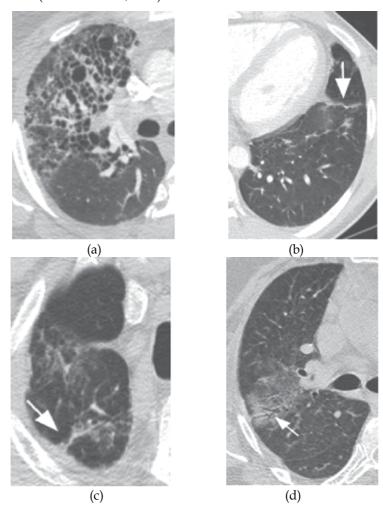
Fibrotic changes in advanced sarcoidosis. (a) A 29-year-old female with sarcodidosis. CT of the chest demonstrates multiple cystic lesions within the left upper lobe, representing areas of honeycombing. (b) A 34-year-old male with sarcoidosis. CT of the chest shows areas of linear densities (arrow) in the left lower lobe compatible with linear scarring. (c) A 49-year-old male with sarcoidosis. CT of the chest demonstrates architectural distortion in the right lung apex (arrow). (d) A 54 year-old female with sarcoidosis. CT of the chest shows bronchiectasis in the right upper lobe.
